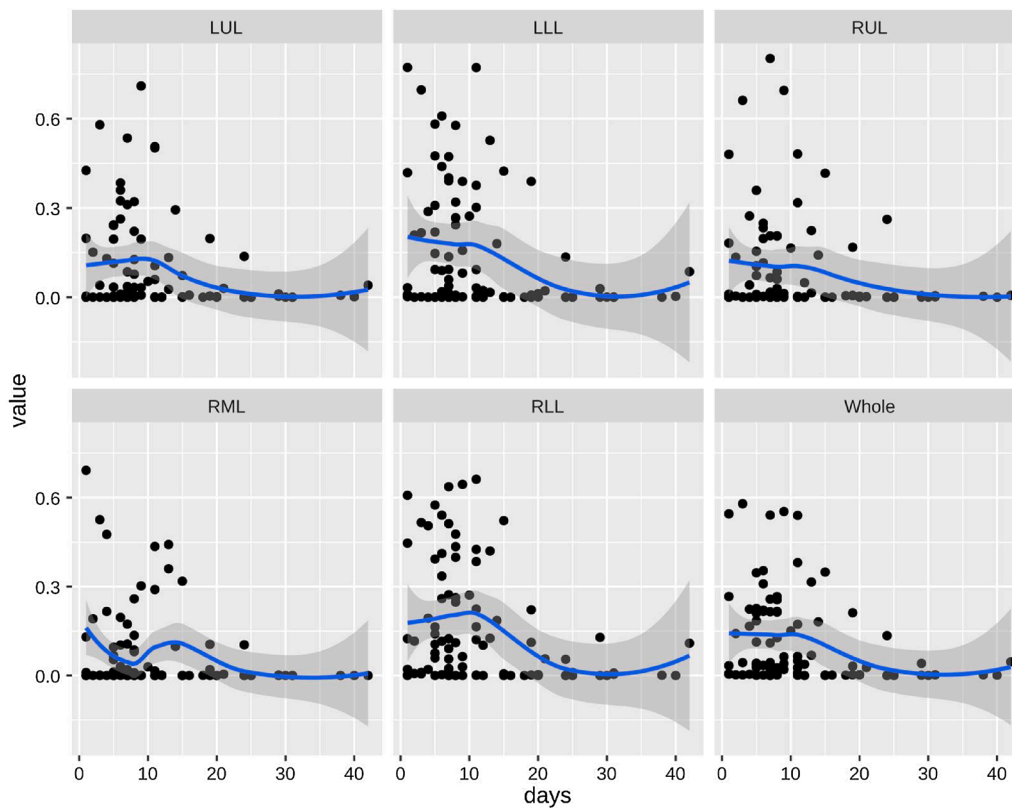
Progression of regions with pulmonary opacities with symptom-onset days for the five lung lobes and the whole lung region. For each subplot, the x-axis stands for the days between symptom onset and the CT scan date and the y-axis stands for the pulmonary opacities ratio of the corresponding lung region. LUL = left upper lobe; LLL = left lower lobe; RUL = right upper lobe; RML = right middle lobe; RLL = right lower lobe; Whole = whole lung region.
